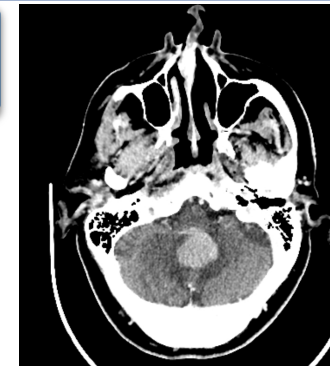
suspected cerebral lymphoma on CT head with contrast.
